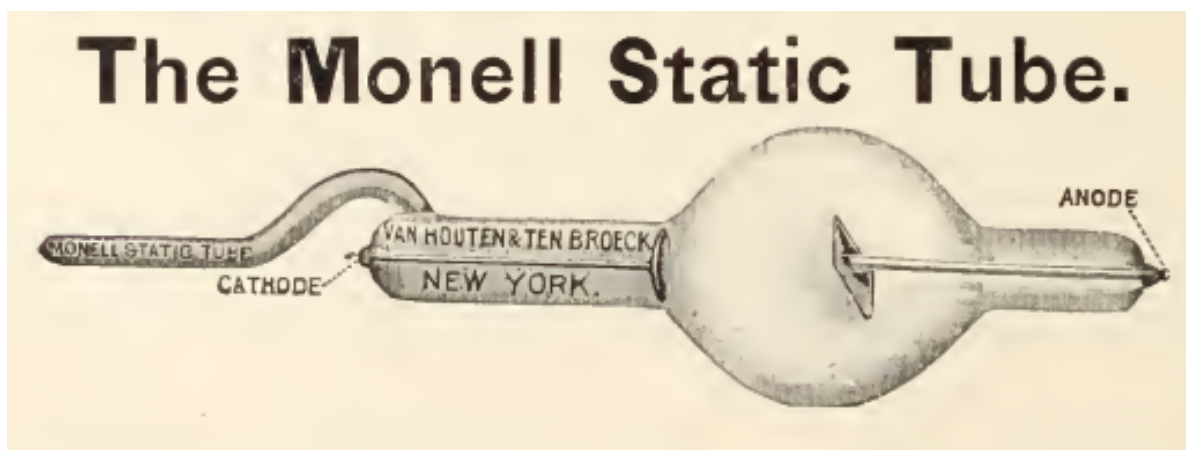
The Monell Static Tube, an example of a vacuum tube used by early radiologists. *American X-Ray Journal*, Vol. 1, p.110.
